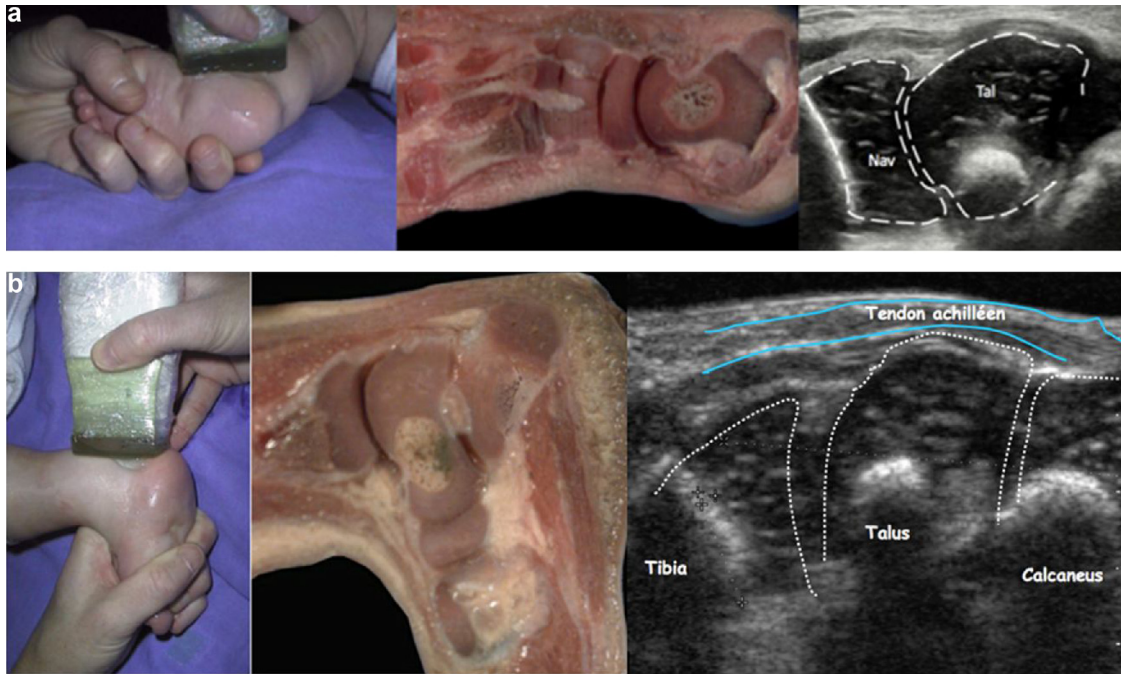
a: position for acquiring the medial axial ultrasound projection, anatomic model, and ultrasound image showing the navicular (Nav) and talus (Tal); b: position for acquiring the sagittal posterior ultrasound projection, anatomic model, and ultrasound image showing the tibia, talus, and calcaneus.
